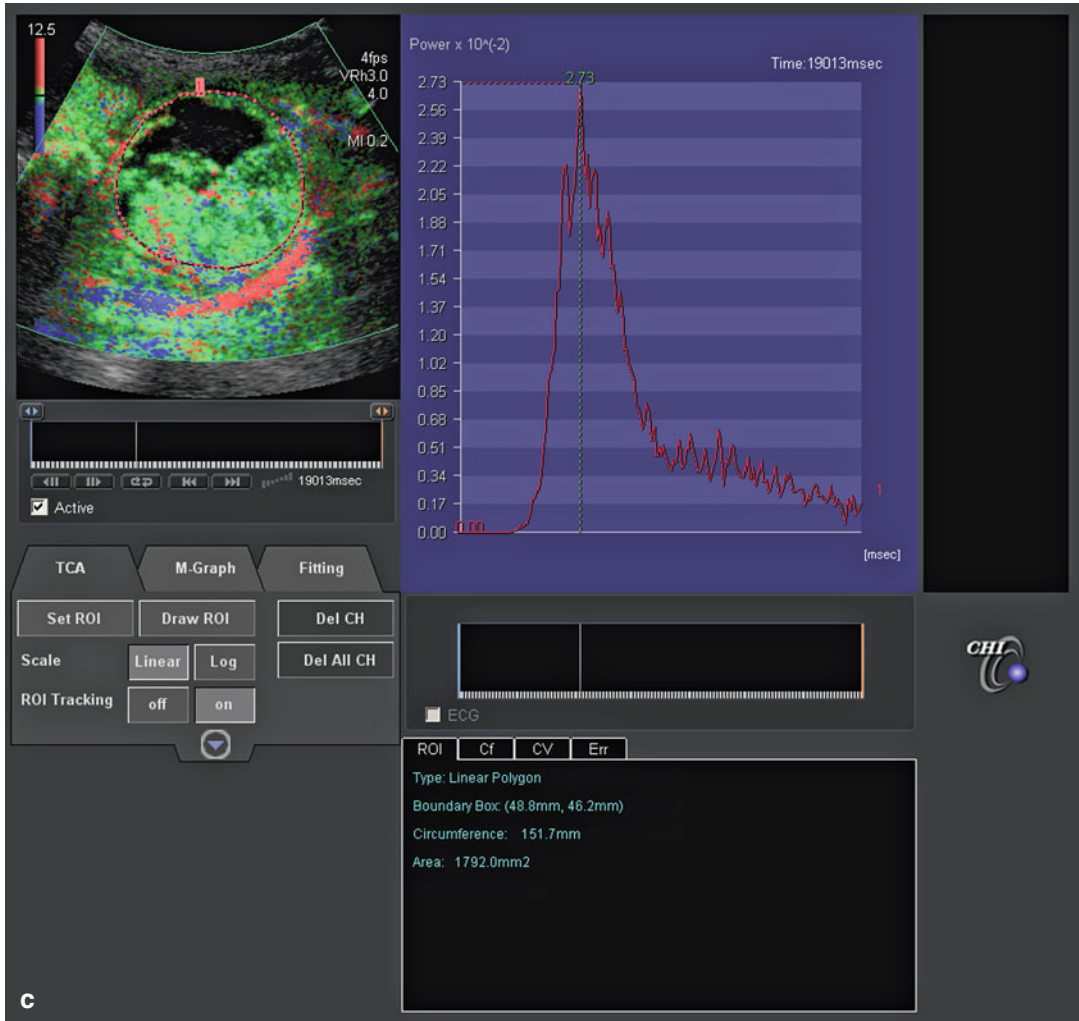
Poor responder, 47-year-old male with melanoma on the left flank, treated with sorafenib and tlemsirolimus. (a) The baseline ultrasound B-Mode image showed a mass measuring 49 mm in largest diameter. (b) DCE-US study showed marked enhancement of the mass after contrast administration. (c) One month later, the lesion had
